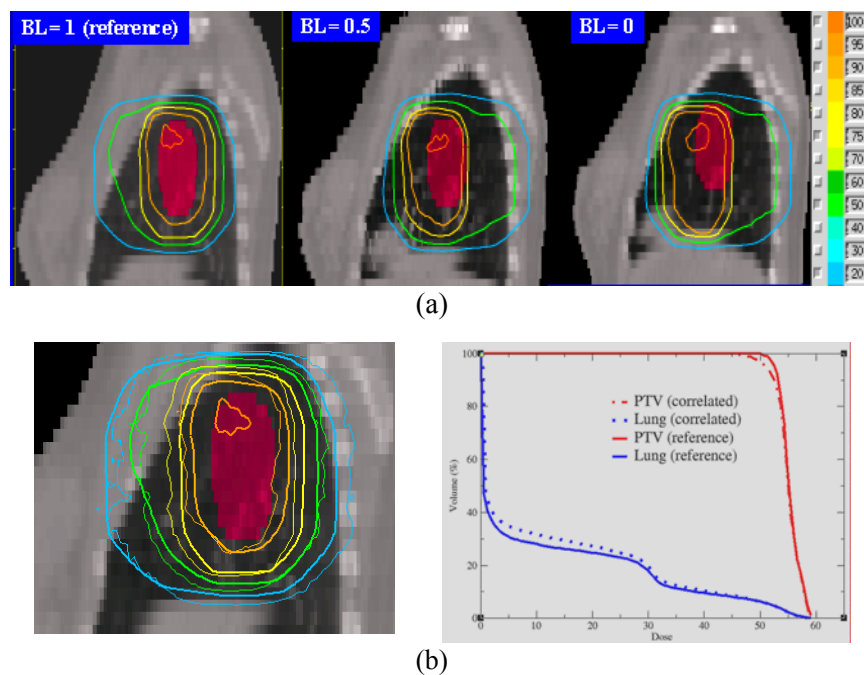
Dose accumulation taking into account breathing motion. (a) Dose distributions for patient CT images at different breathing levels,  $BL=1$ , 0.5 and 0.  $BL=1$  was chosen as the reference. (b) Comparison of the reference and accumulated dose distributions and their DVHs. For dose distributions, thick lines are for the reference and thin lines are for the accumulated dose. For DVHs, solid lines are for the reference CT image, dashed and dotted lines are for the accumulated dose distribution.
